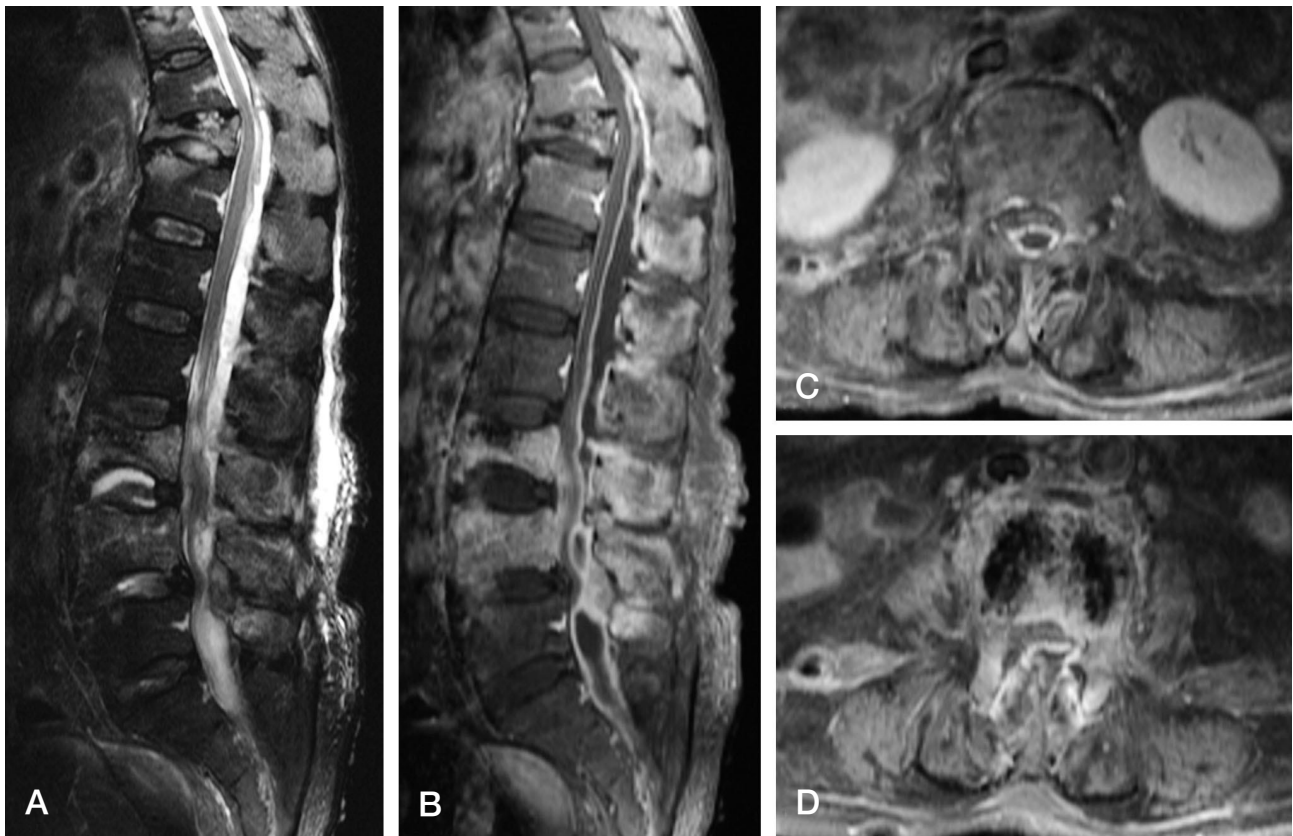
T2 weighted sagittal MR image demonstrates high signal intensity of L3-4 body and epidural space and subcutaneous space (A). Enhanced T1 weighted MR images demonstrate low signal intensity with ring-like peripheral rim enhancement of epidural lesion, suggestive of spinal epidural abscess from T10 to S1 (B). An axial image of L2 level demonstrates compression of spinal cord by a huge spinal epidural abscess (C). An axial image of L3 body level (D).
